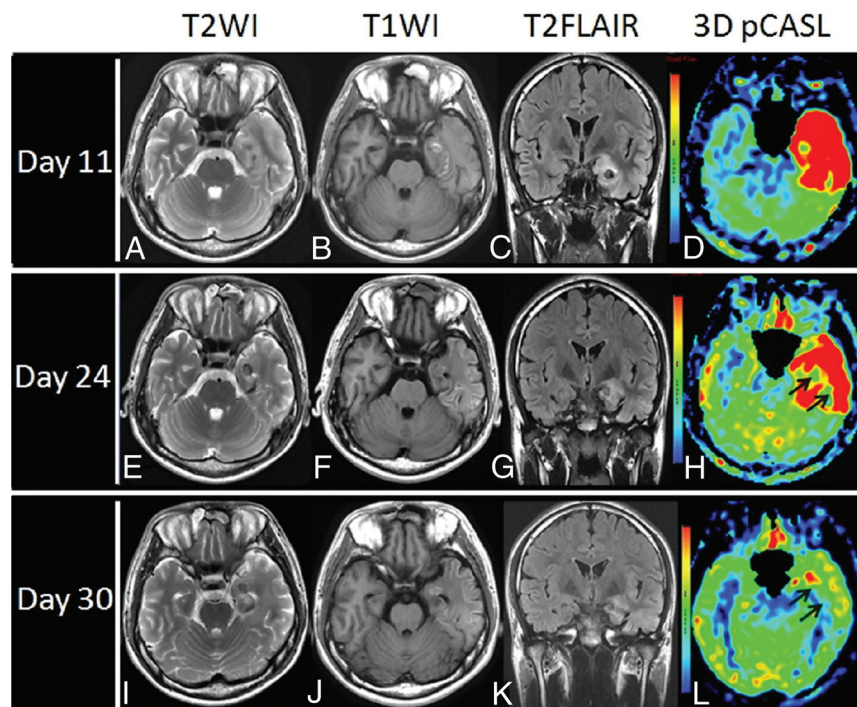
Case 1, a 17-year-old male patient. Serial T2WI (A, E, and I), T1WI (B, F, and J), and coronal T2 FLAIR (C, G, and K) demonstrate abnormal signals on the left temporal lobe and hippocampus. Serial follow-up 3D-pCASL perfusion imaging was performed, which reveals dynamic changes in the involved area on the 11th (D), 24th (H), and 30th day (L), respectively (black arrows). Meanwhile, the patient's condition markedly improved with effective therapeutic intervention.
